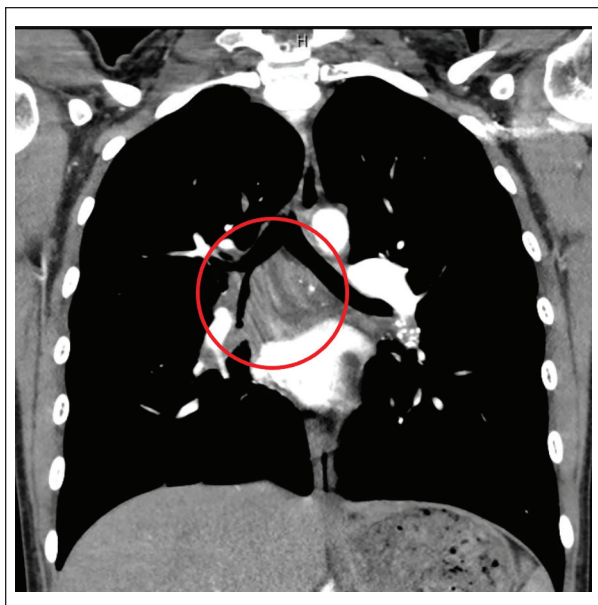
Coronal image of computed tomography scan of thorax with contrast showing a 4.6-cm calcified soft tissue mass and bilateral hilar lymphadenopathy causing mild compression of the right middle lobe bronchi.
